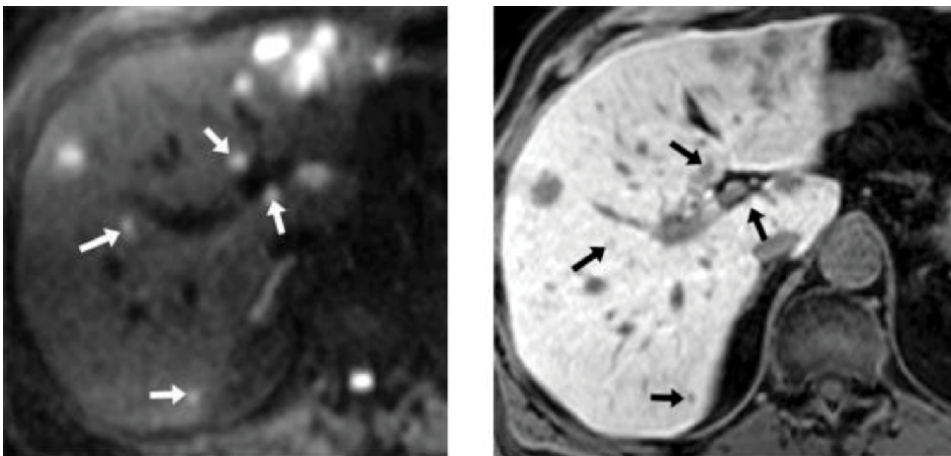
Comparison of diffusion-weighted MRI with contrast-enhanced T_1 W MRI. Left: diffusion-weighted MRI of liver metastases. The arrows indicate small metastatic tumors, less than 1 cm diameter. Right: CE- T_1 W image after applying Gd-EOB-DTPA, in the same patient. Reprinted with permission from Koh and Berry [74].
